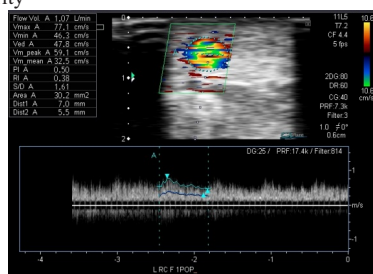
showing ultrasound measurement of flow volume in draining vein.
